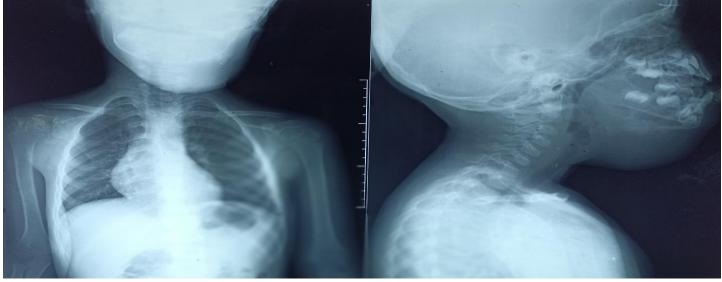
Chest X-ray anteroposterior view: Unremarkable; X-ray head & neck lateral view showing radiolucent soft tissue welling in submandibular and submental region
